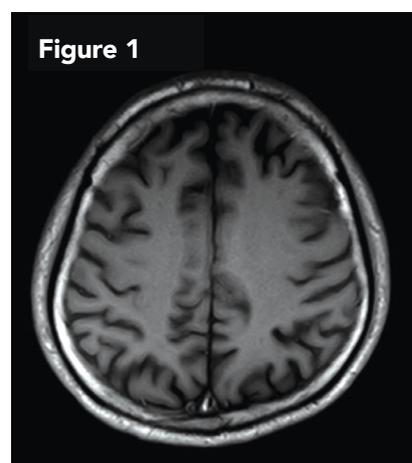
MRI Brain showing predominant bilateral parietal atrophy
